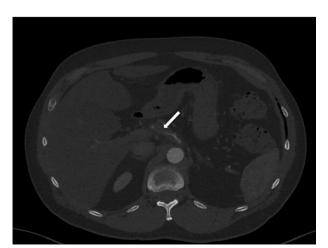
Abdominal CTA showing progression of the intramural hematoma to near occlusion of the hepatic artery.
